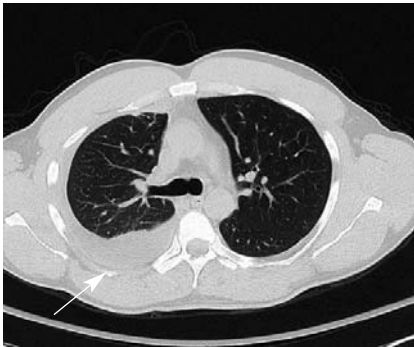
CT confirmed the effusion and also showed thickened pleura and partial loculation of the fluid.
